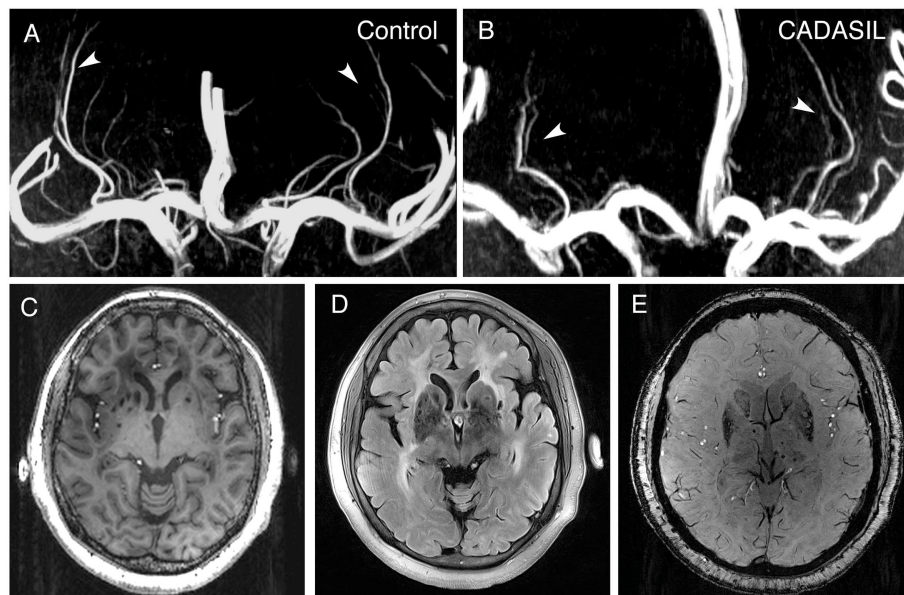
7.0-T MRI images of patients with CADASIL. (A) Representative LSA image of a 37-year-old healthy woman obtained using 7.0-T TOF-MRA. Arrows indicate bilateral arteries. (B) Representative LSA image of a 39-year-old woman with CADASIL obtained using 7.0-T TOF-MRA. Arrows indicate bilateral arteries. Compared to healthy control, decreased number of LSAs and increased proportion of discontinuous LSAs can be observed. (C) T1-weighted sequence of a 51-year-old woman with CADASIL demonstrating LIs in the basal ganglia. (D) FLAIR sequence of the same patient displaying WMHs and LIs in the basal ganglia. (E) SWI sequence of the same patient exhibiting CMBs. LSA, lenticulostriate artery; LIs, lacunar infarctions; WMHs, white matter hyperintensities; CMBs, cerebral microbleeds.
